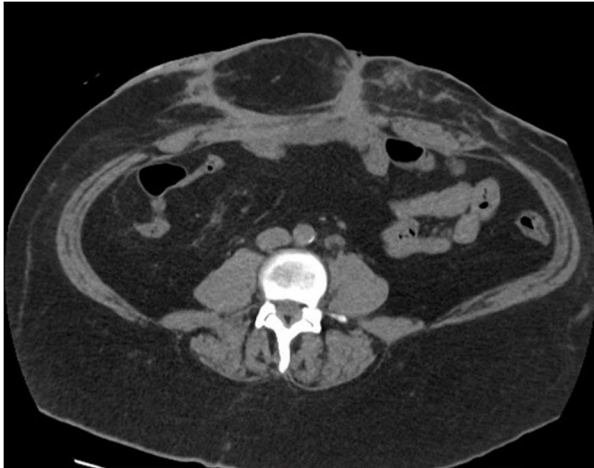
CT scan before discharge. No dehiscence along median laparotomy.
